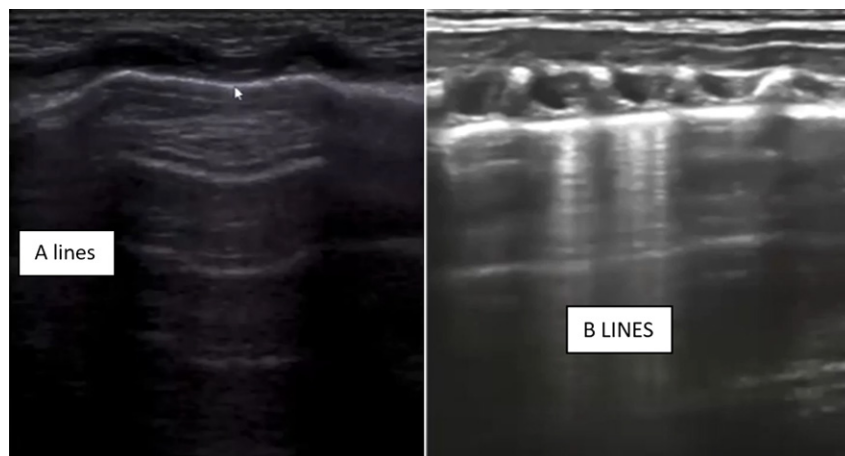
Lung Ultrasound showing A & B lines
